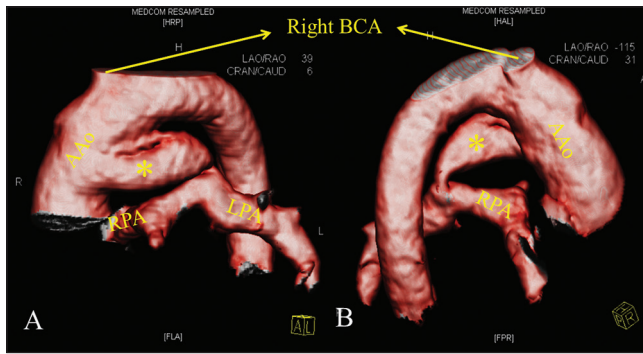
CT angiographic images reconstructed using volume rendering technique (VRT) in right anterior oblique view (panel A) and left posterior oblique view (panel B). The vascular channel (*) supplying the pulmonary arteries originates from the ascending aorta. The origin is unequivocally proximal to the origin of the brachiocephalic artery and it terminates into the pulmonary artery confluence at the usual sight of patent arterial duct making it very likely to represent the fifth arch artery. The narrowing at the pulmonary end is visualized in panel B. AAO = Ascending aorta, LPA = Left pulmonary artery, RPA = Right pulmonary artery, BCA = Brachiocephalic artery
